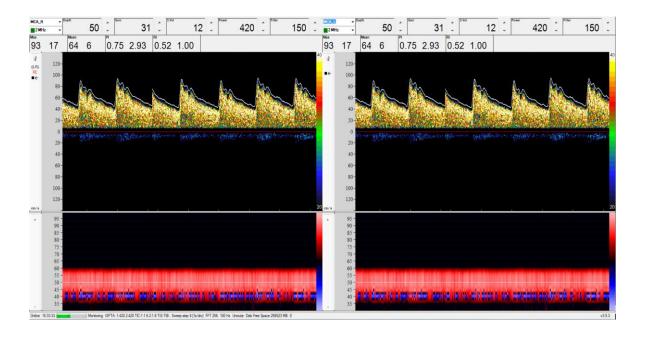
A screenshot of a typical middle cerebral artery velocity trace at baseline, acquired via TCD ultrasound.
